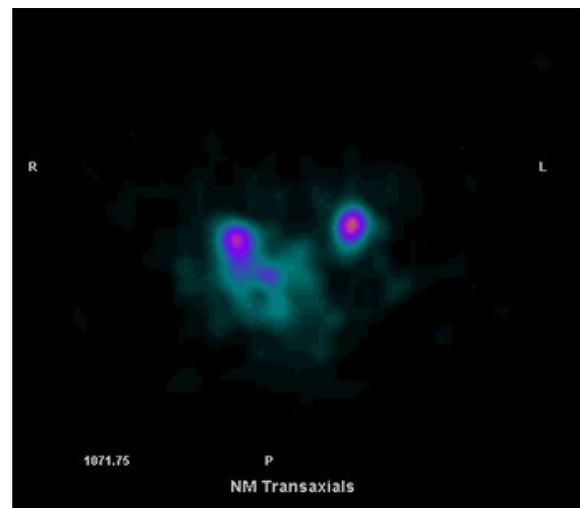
Lymphoscintigraphy showing bilateral tracer migration after intracervical injection of Tc-99m
